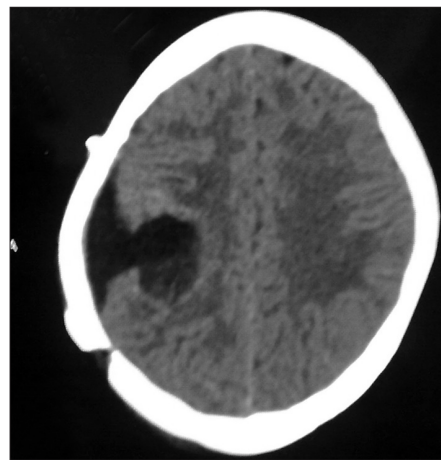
Postoperative CT scan Image
